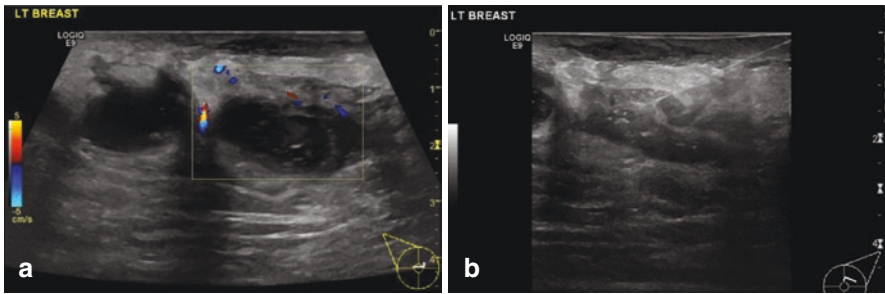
(a) A 31-year-old woman with recurrent breast abscess. Ultrasound shows two collections with internal complex echoes with surrounding parenchymal inflammation with hypervascularity. (b) Ultrasound-guided aspiration
